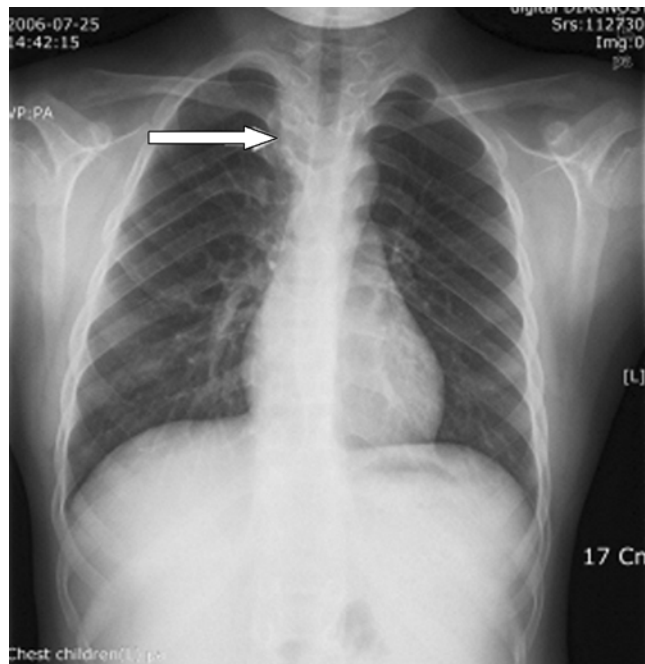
Chest x-ray shows bifidity of ribs.
